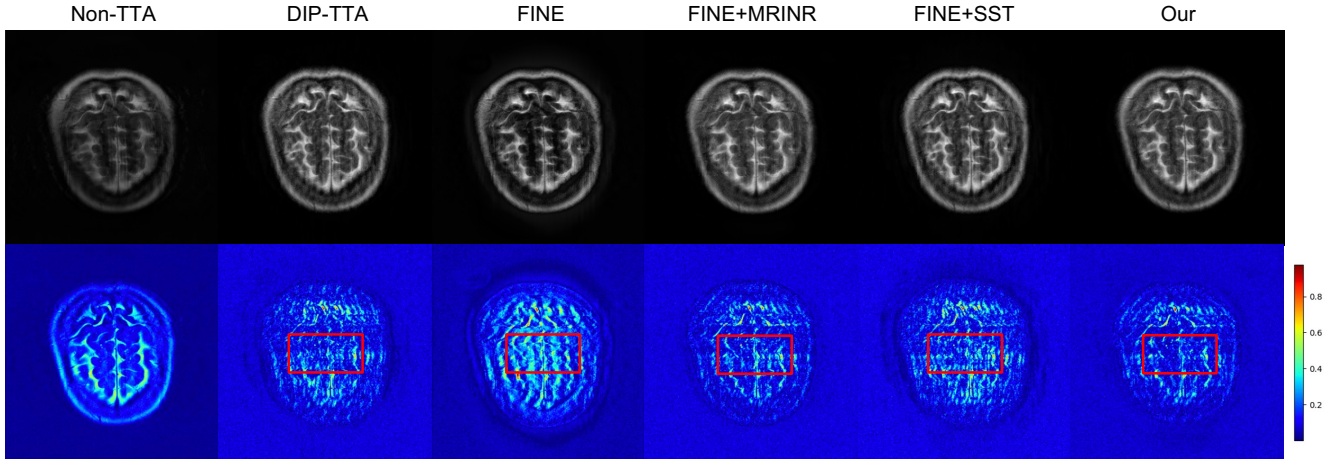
Comparison of different frameworks in VarNet under anatomy shift (Knee to Brain) using the FINE method. The first row shows reconstructed MRI images, while the second row presents residual maps between reconstructions and full-sampled MRI.
